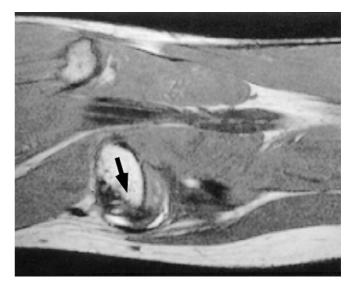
Magnetic resonance image of inflamed tissue at the posteromedial capsular insertion of the semimembranosus tendon due to an inappropriate arrow length
